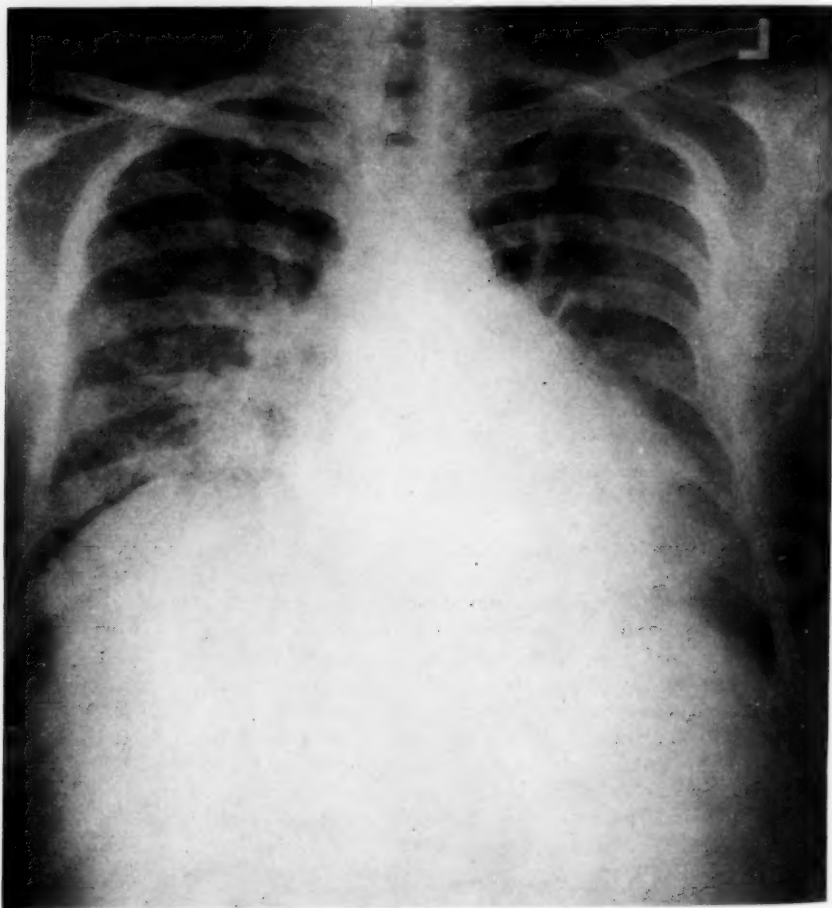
Roentgenological appearance of the chest about two weeks later, 3-24-33. Clinically improved.
